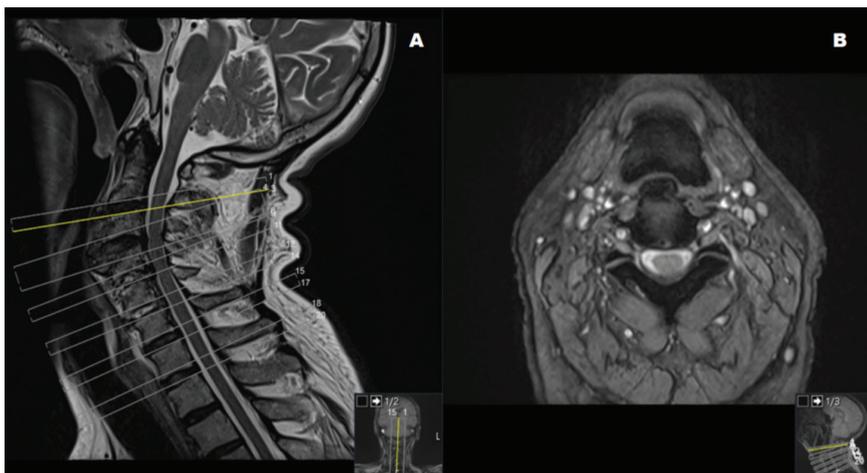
Preoperative MR images (A) sagittal reconstruction (B) axial scan.
